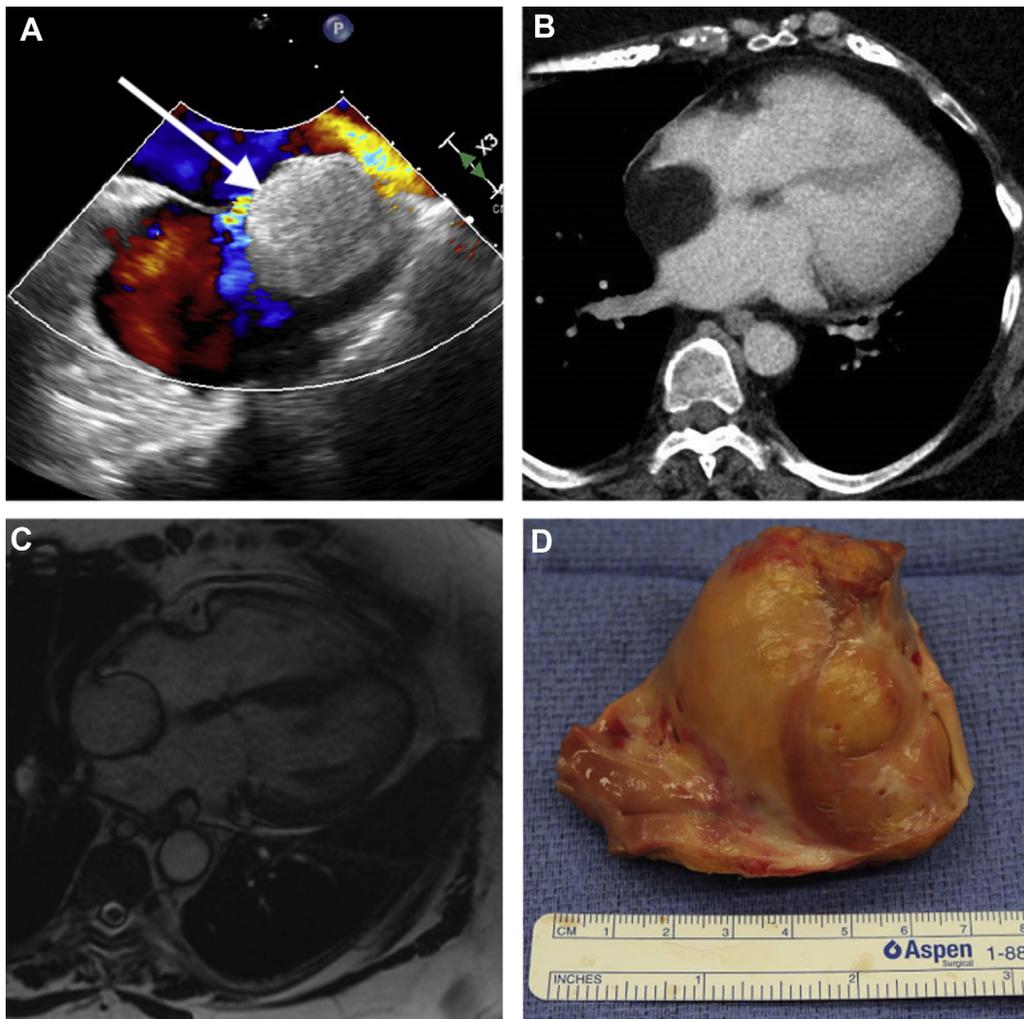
Transesophageal echocardiogram, computed tomography, cardiac magnetic resonance imaging, and resected cardiac mass. A: Transesophageal echocardiogram demonstrated a well-defined interatrial cardiac mass with sparing of the fossa ovalis indicated by the *white arrow*. Patent foramen ovale with left-to-right atrial shunt on color Doppler. B: Computed tomography showed a non-enhancing interatrial cardiac mass with a radiological appearance consistent with fat. C: Cardiac magnetic resonance imaging showed a well-circumscribed interatrial cardiac mass with signal characteristics similar to fat. D: Resected cardiac mass.
